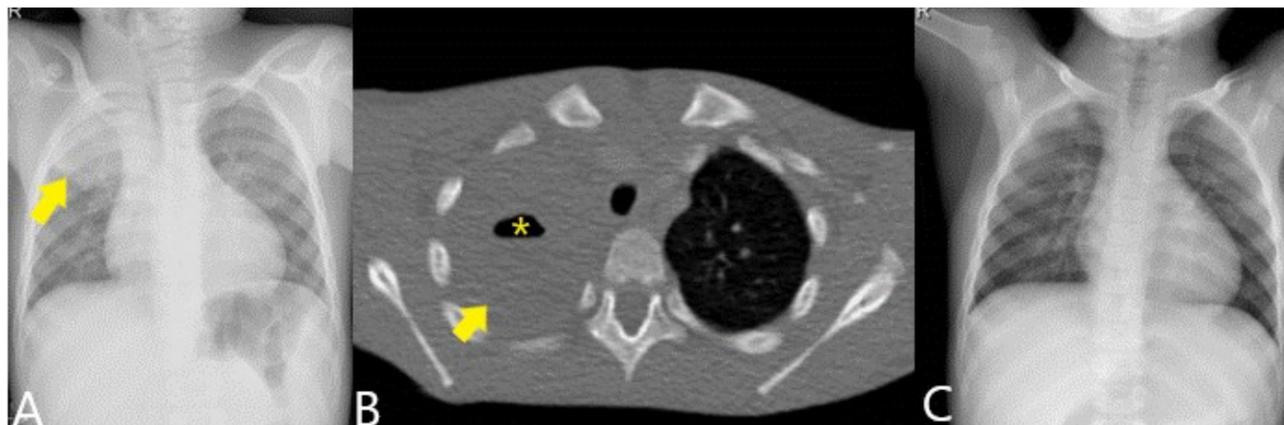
Chest X-ray (A) showing condensation in the right upper lobe (arrow). Contrast-enhanced CT (B) shows the condensation (arrow) with the presence of an air level suggestive of cavitary pneumonia (asterisk). The control radiograph (C) shows complete resolution of the picture.
